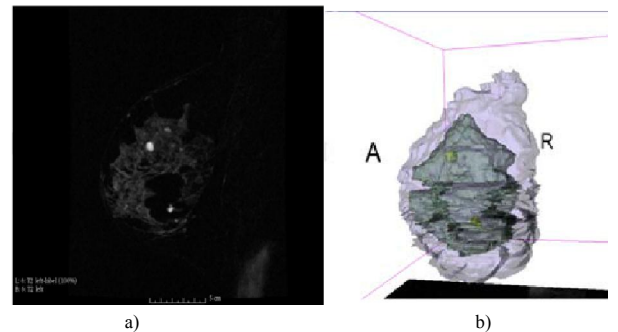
a) MRI of a left breast, b) volumes reconstructed from DICOM data.
